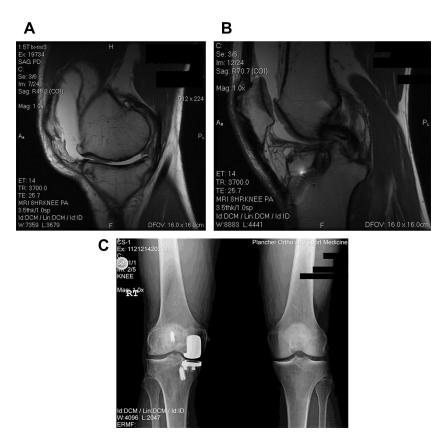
(A) Magnetic resonance (MR) arthrogram sagittal proton density image of medial compartment OA in an ACL-deficient knee. (B) MR arthrogram sagittal proton density image of the same patient with a failed previous ACL reconstruction in a medial compartment osteoarthritic knee. (C) Postoperative plain radiograph of UKA in ACL-deficient knee in the same patient.
